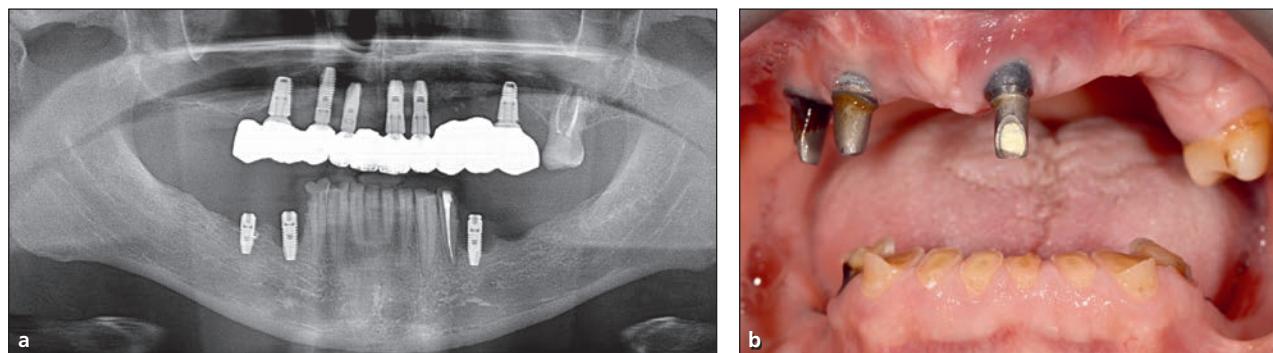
(a) Radiograph of initial situation showing peri-implantitis around implants in the maxilla and mandible. (b) Initial clinical situation.
